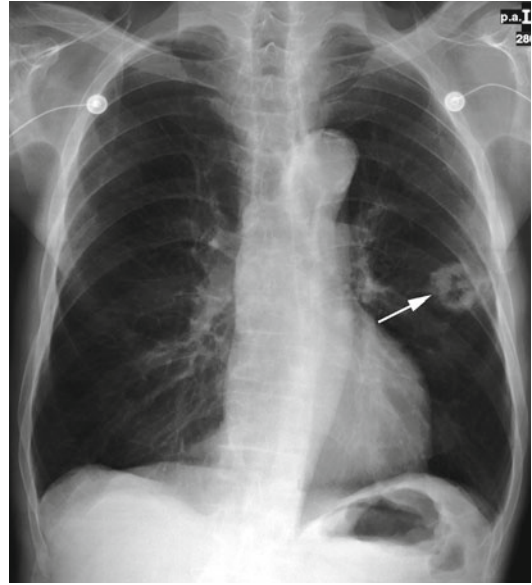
Frontal chest radiograph reveals cavitary lung cancer in left upper lobe (*arrow*)
